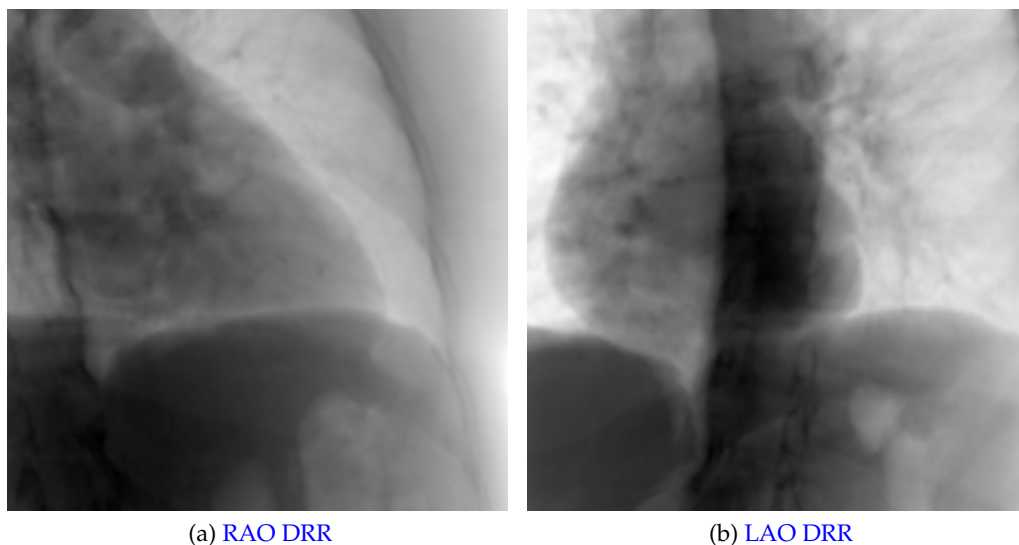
DRRs generated from a CT volume to assess manual registration performance. (a) RAO 30° and (b) LAO 30° projections to resemble standard CRT working angulations.
